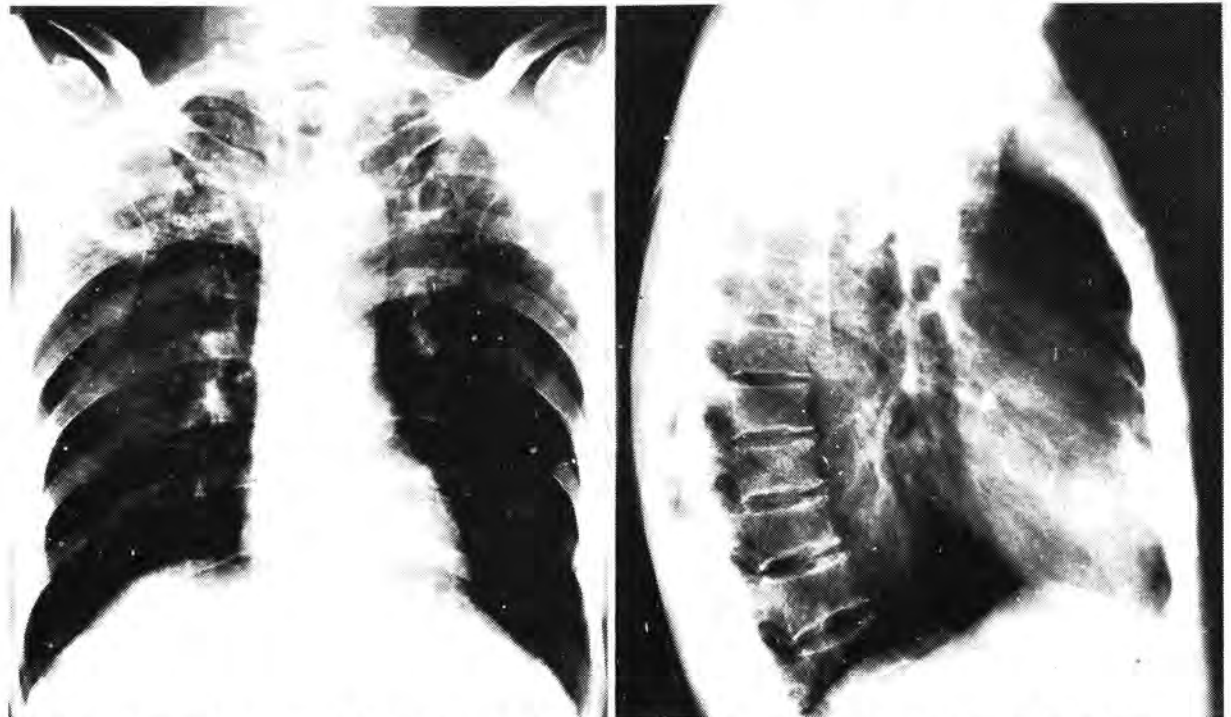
Chest x-rays of a 60-year old man with a history of night sweats and chronic cough. Note the bilateral apical scarring typical of chronic pulmonary tuberculosis.
